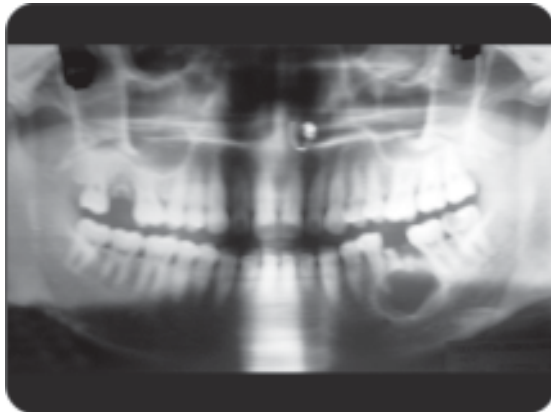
Radiograph of radicular cyst
